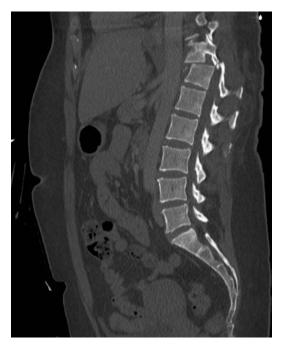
Parasagittal trauma CT showing locked facets at T11/12
